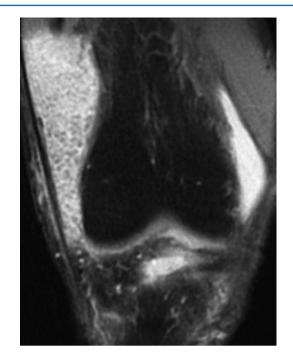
Coronal fat-saturated T2-weighted magnetic resonance image revealing numerous low-signal osteochondral bodies
